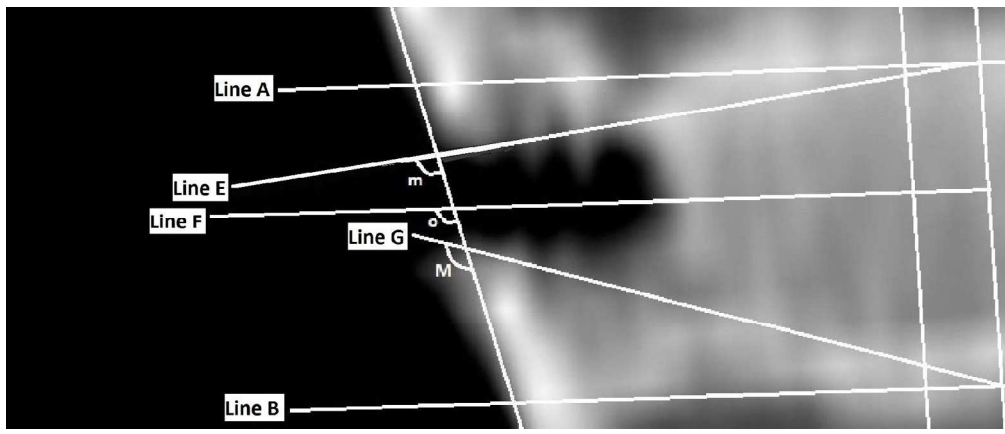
close-up. CT evaluation of the dorsoventral safe corridor in the dorsal plane (close-up).
